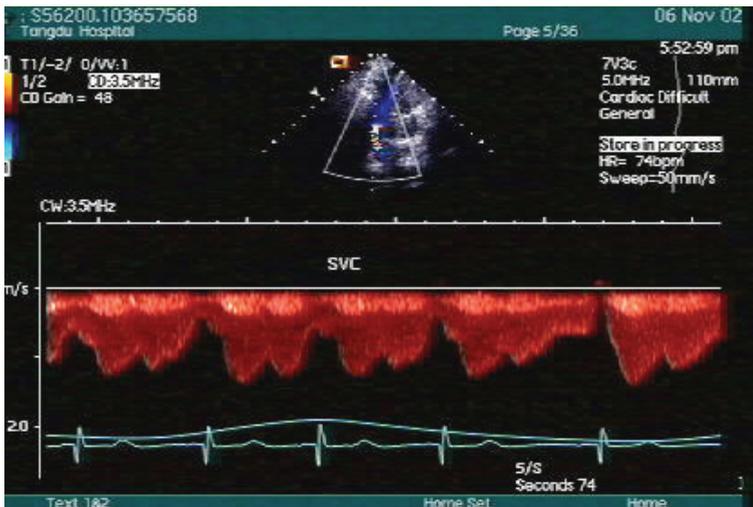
SVC Doppler flow spectra in mild SVCS. The forward waves showed high velocity and no distinct spectral window
